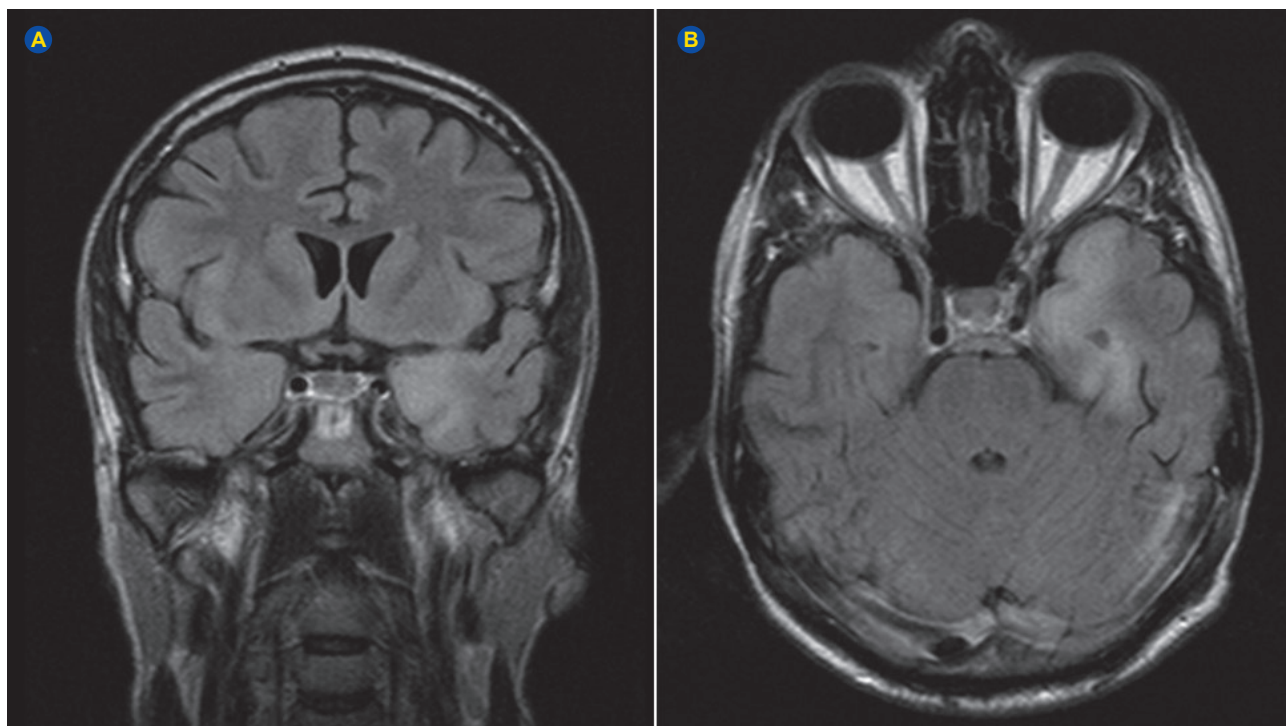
MRI in February 2019 showed hyperintense signal on T2/FLAIR on the medial left temporal lobe in coronal and axial planes, respectively
